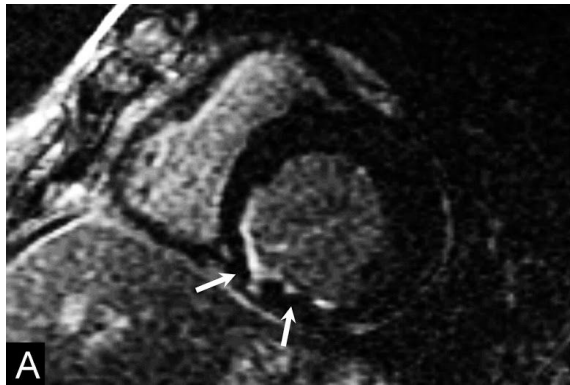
DCE-MRI image showing a tear on the inferior and inferoseptal walls indicated by the arrow.²²
